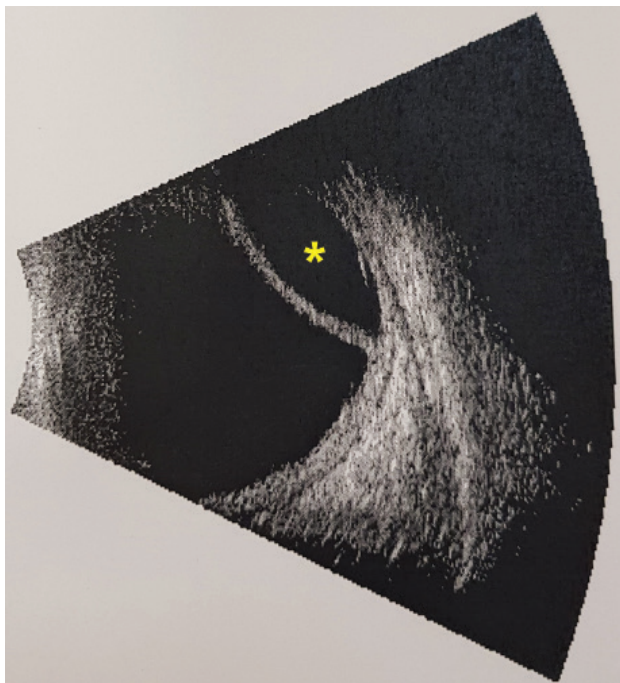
Ultrasound B scan of the left eye, choroidal detachment (star)
